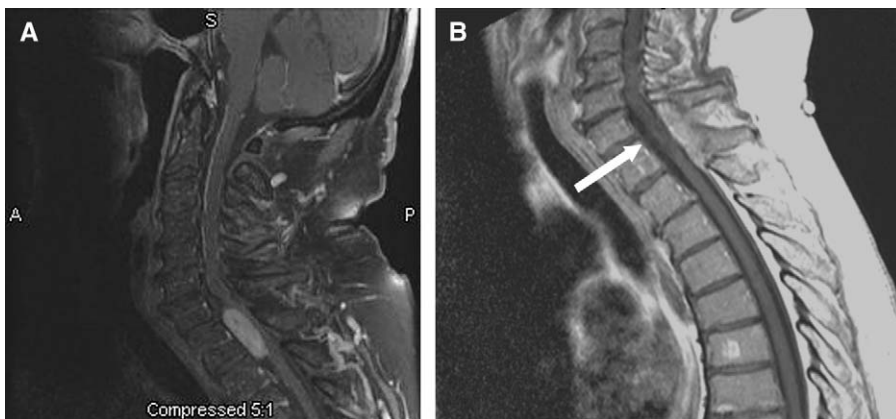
A 70-year-old man presented with chronic myelopathy secondary to a thoracic schwannoma. (A) Sagittal T1-weighted MRI with gadolinium demonstrates a well-demarcated, ventrolateral, enhancing, lobular IDEM mass extending from the level of the C7-to-T1 disc space to behind the T2 body. (B) Postoperative T1-weighted MRI with gadolinium reveals complete resection of the tumor (arrow) with minimal impact on the posterior spinal structures.
